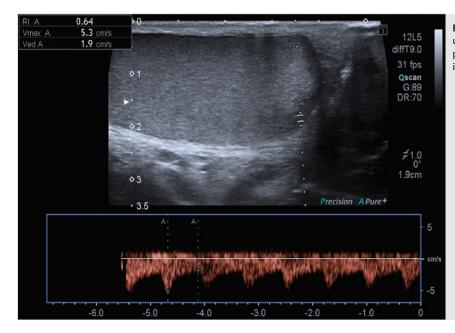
Seminoma of the testis. Color Doppler ultrasound shows a hypoechoic area, with tiny peripheral color flow signal with low resistivity index (RI).
